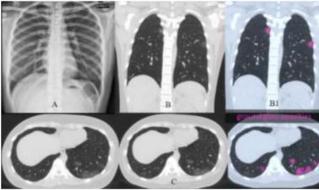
A. A chest X-ray and an coronal (B), axial (C) CT image in a 25-year-female mild common type Covid-19 patient (, atypical symptom/sinusitis onset, 3 days from normal sinus paranasal X-ray to chest X-ray and CT scan) shows multiple GGO in peripheral distribution both lungs.
